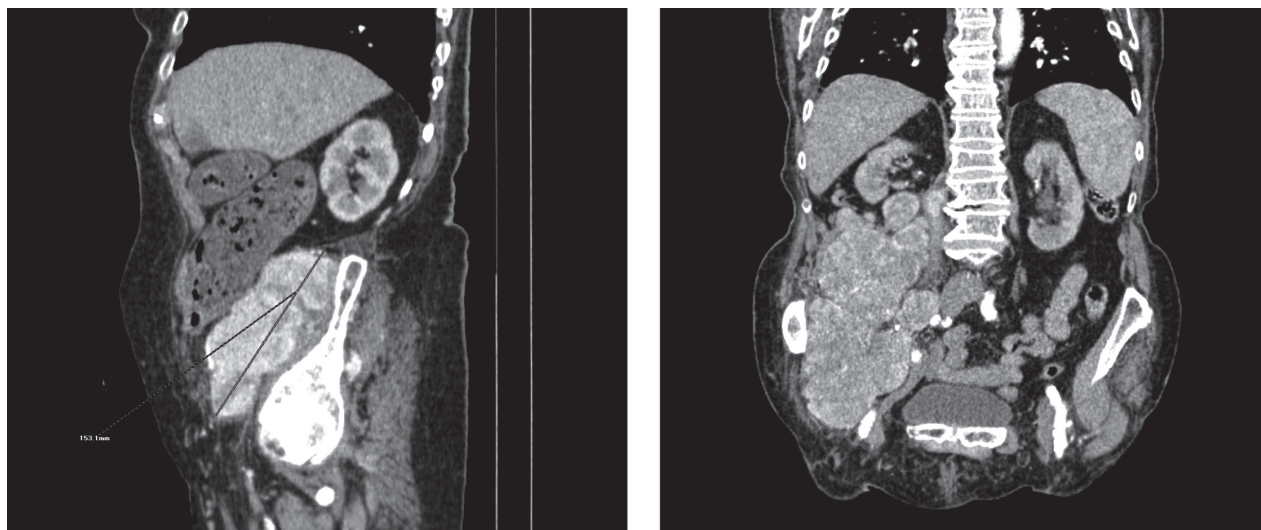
The Computed tomography images shows the big Haemangiopericytoma
